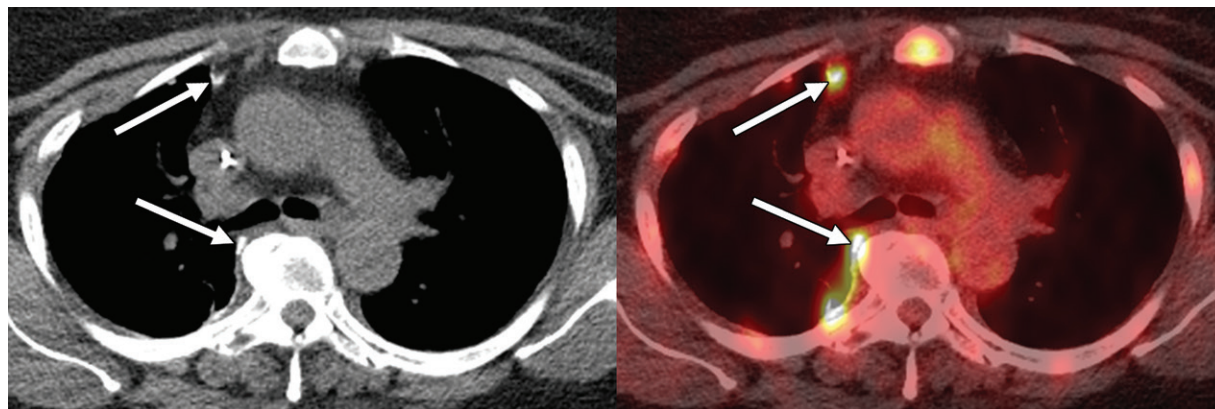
Findings after talc pleurodesis for recurrent right pleural effusion in a 59-year-old woman with acute lymphocytic leukemia. Restaging transaxial CT (left) and fused FDG PET/CT (right) images show focal right pleural FDG uptake (arrows in right image) with corresponding high-attenuation foci at CT (arrows in left image), compatible with inflammatory changes from talc pleurodesis performed 1 year ago. Focal uptake in the sternum is favored to represent leukemic involvement.
